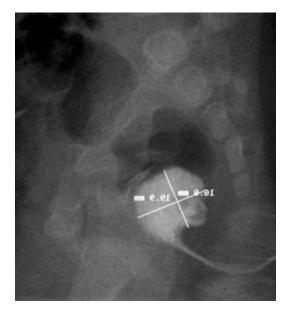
Lateral contrast X-ray of the anal canal duplication
